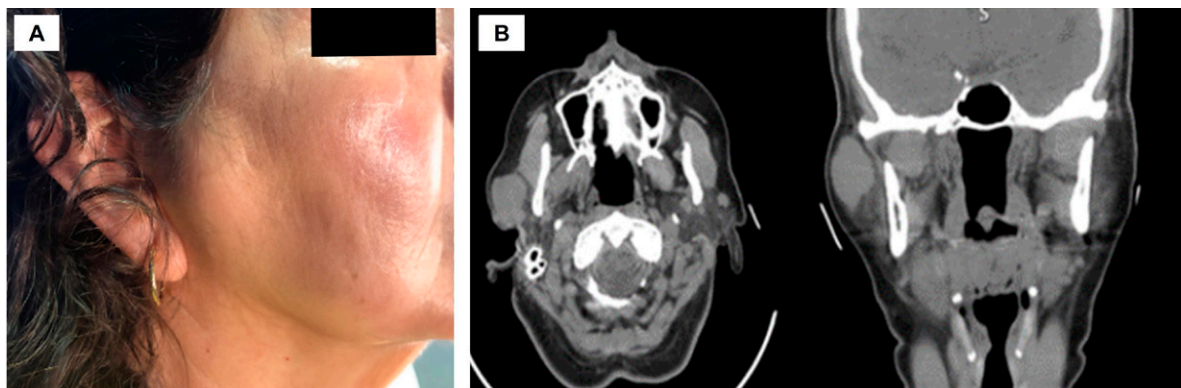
Initial images. A. Lateral extraoral photograph of the preauricular region showing the volume augmentation in the parotid region, without changes in the skin. B. Computed tomography in two slices at the level of the atlas for the axial view and at the level of the nasopharynx in the coronal view. The transverse view shows an isodense area with poorly defined edges associated with the parotid gland. The coronal view reveals well-defined edges in the right preauricular region.
